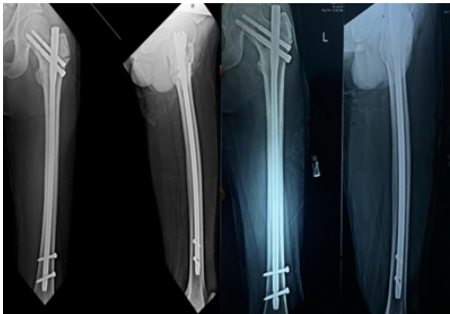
And 3 Month Follow Up Xray
